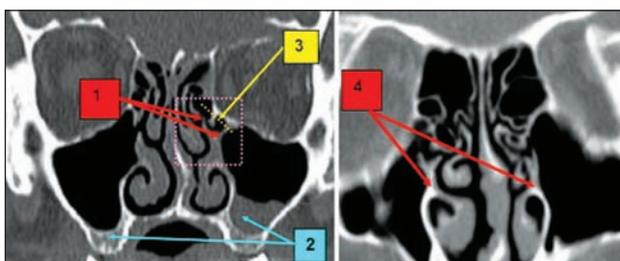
Paranasal sinuses CT scan, coronal reconstruction: 1. elongated, fractured, left uncinatoprocess, inserted into the lamina papyracea; 2. pathologic process in the maxillary sinuses; 3. lamina papyracea; 4. bilateral bifid uncinatoprocess
